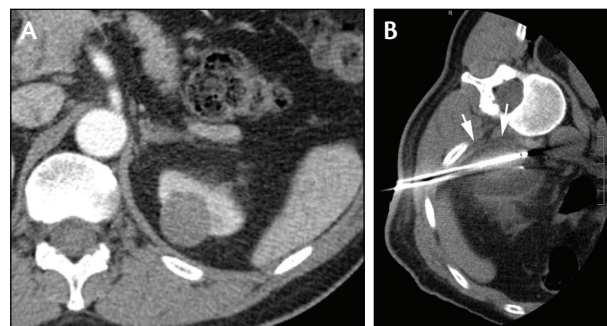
Axial postcontrast CT image demonstrated a hypo-enhancing left renal mass suspicious for renal cell carcinoma, which was in close proximity to the left 12th rib (A). Axial noncontrast CT image obtained in the left lateral decubitus position during percutaneous cryoablation showed that the ice ball margin (arrows) extended into the body wall and abutted the 12th rib (B).
